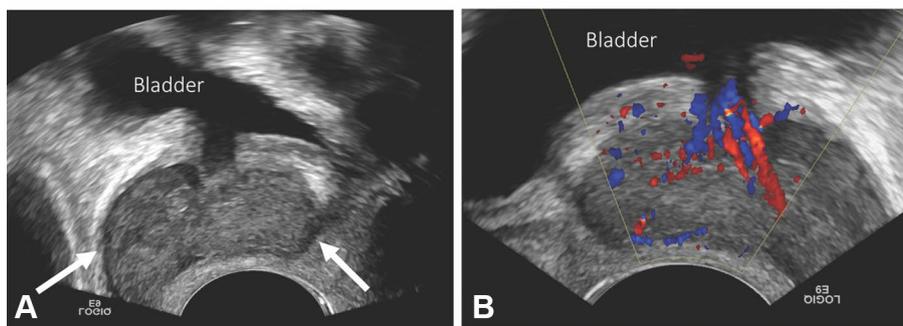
A 59-years-old woman underwent ultrasound for urinary retention and pelvic pain. a Angling the transvaginal probe anteriorly towards the urethra reveals a large mass in the expected location of the urethra (arrows), demonstrating vascular flow on color Doppler ultrasound (b). T2-weighted images in the axial (c) and sagittal (d)
